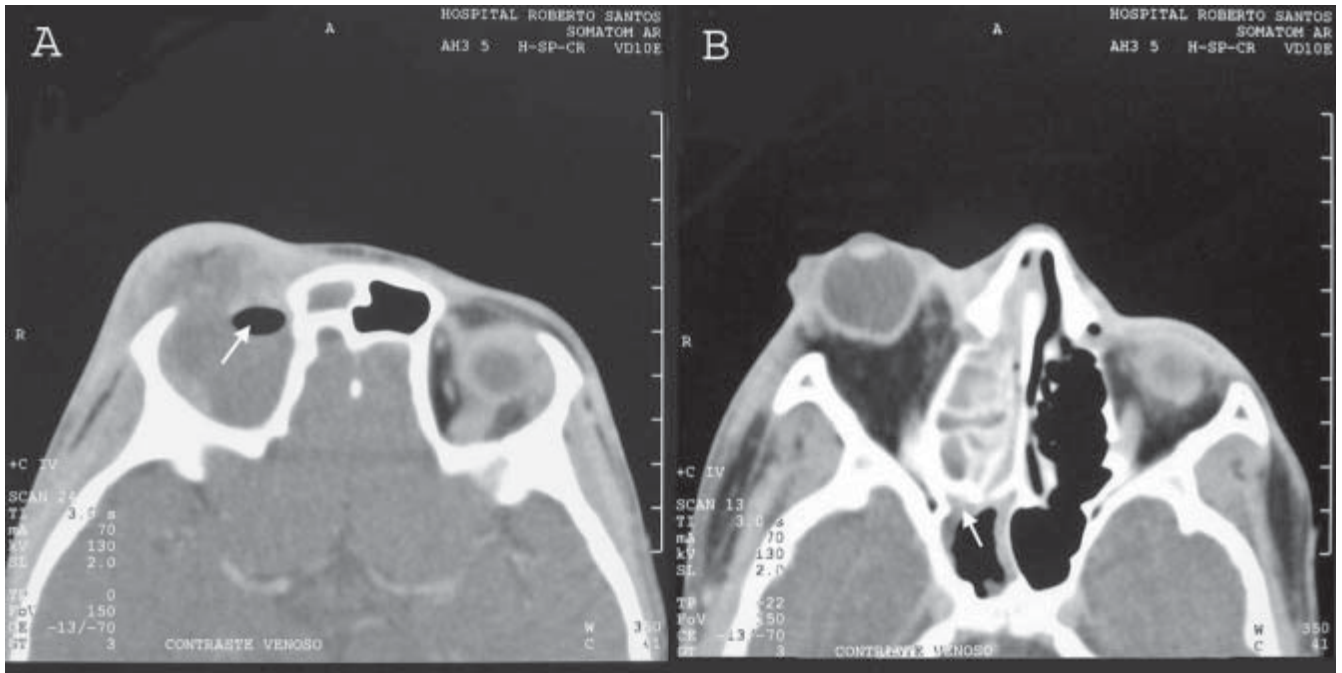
Computed tomography. Axial section. Emphisema (arrow) inside the orbit and the sinusitis at ethimoidal cells and right side of the frontal sinus (A). The right side of the sphenoidal sinus mucosa was inflamed (arrow) (B)
